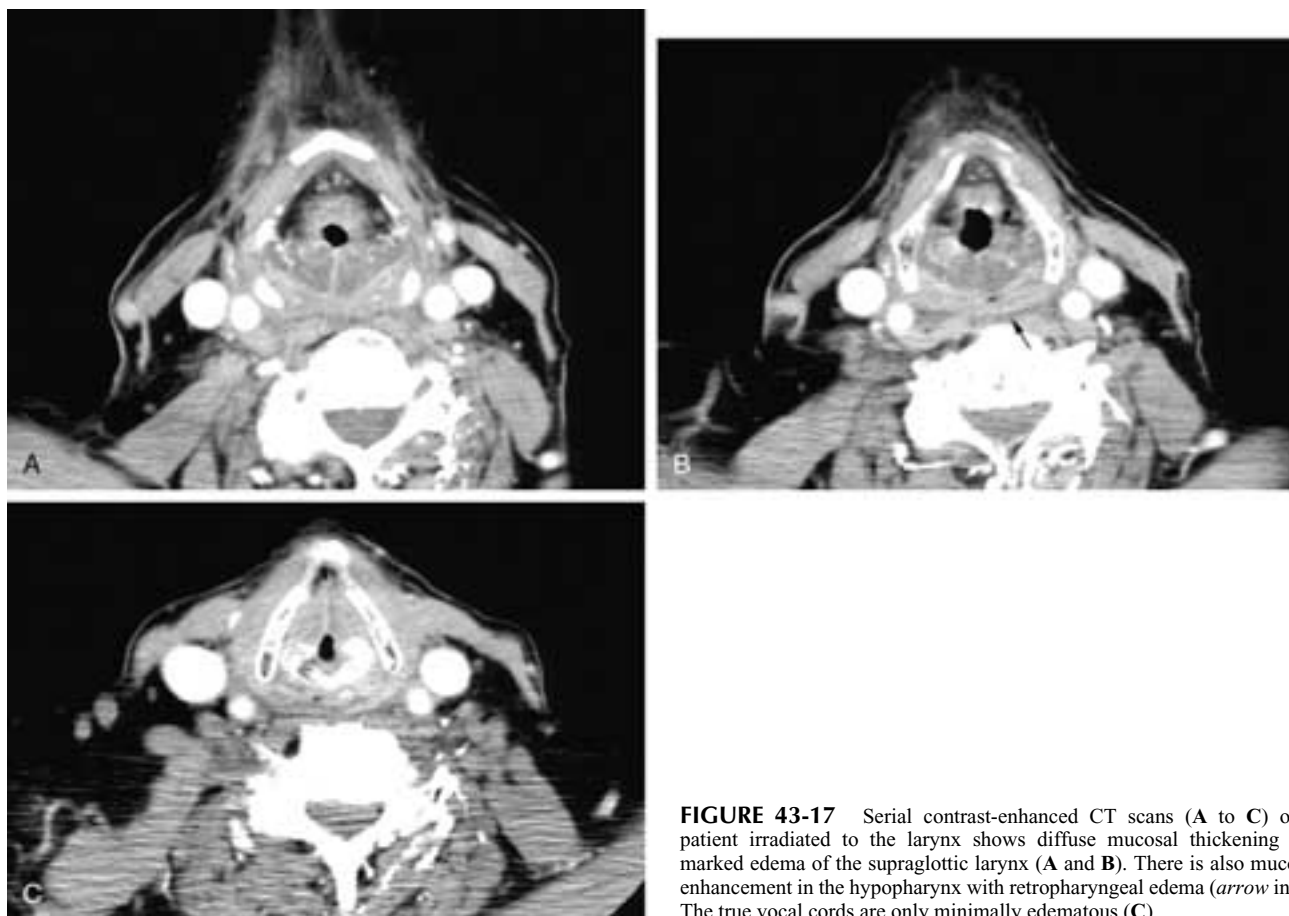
Serial contrast-enhanced CT scans (A to C) on a patient irradiated to the larynx shows diffuse mucosal thickening and marked edema of the supraglottic larynx (A and B). There is also mucosal enhancement in the hypopharynx with retropharyngeal edema (*arrow* in B). The true vocal cords are only minimally edematous (C).
